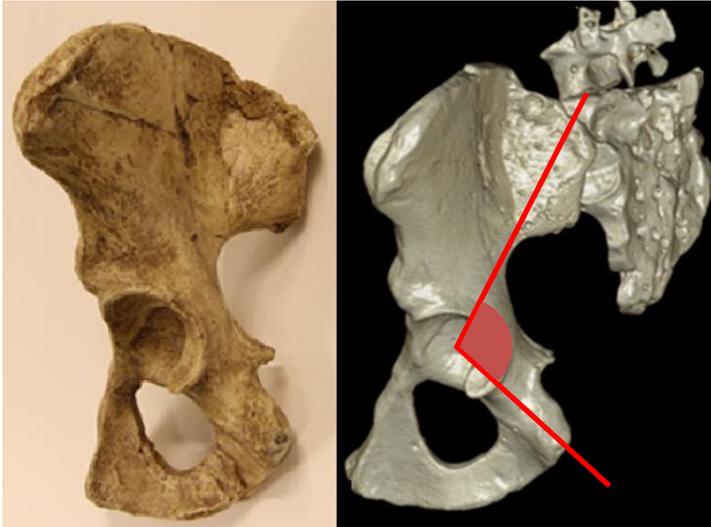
A photograph and three-dimensional reconstruction of a computed tomographic scan of Lucy's pelvis (*Australopithecus afarensis*). The pelvic lordosis (i.e. ischio-iliac angulation) is indicated in red.
